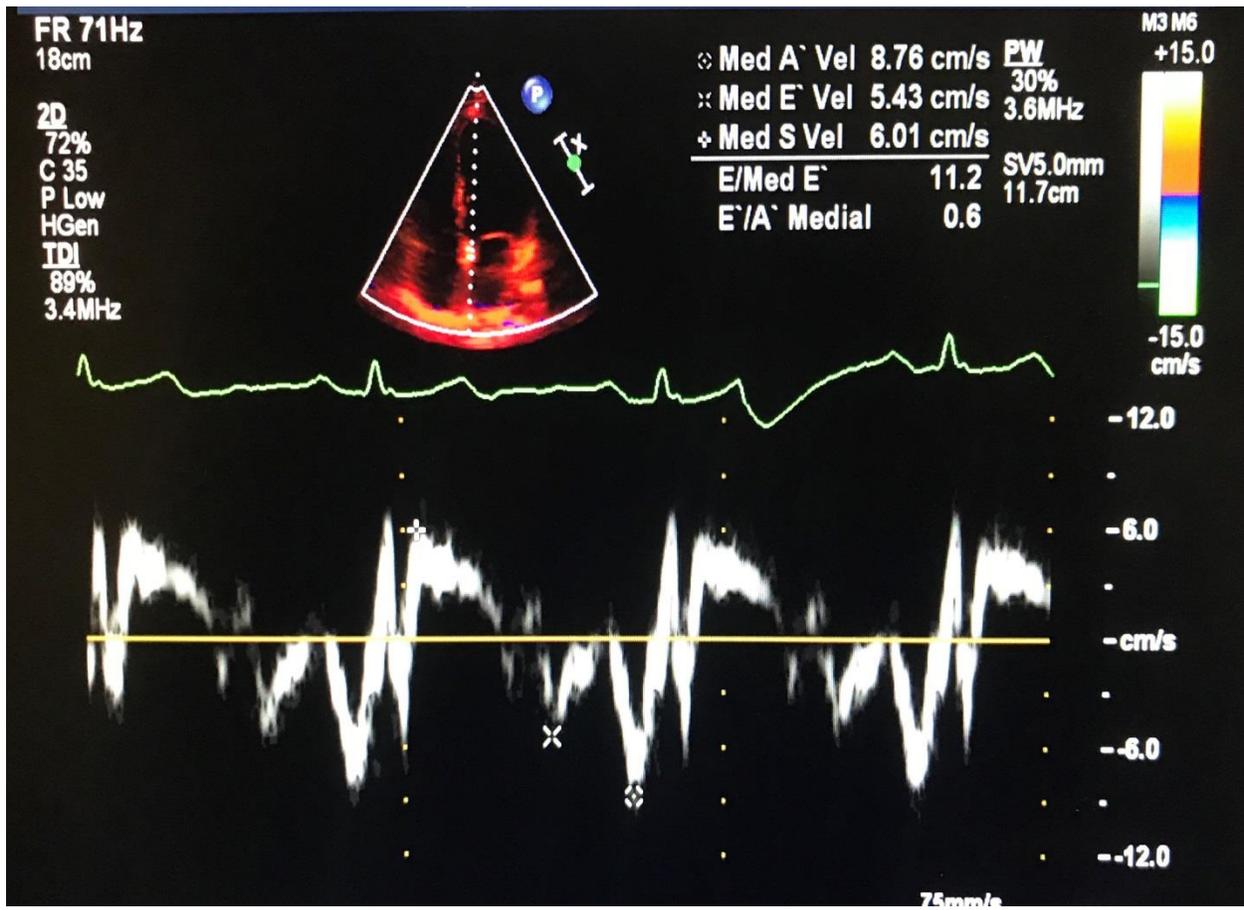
Tissue Doppler imaging of septal segment of LV during rest.
